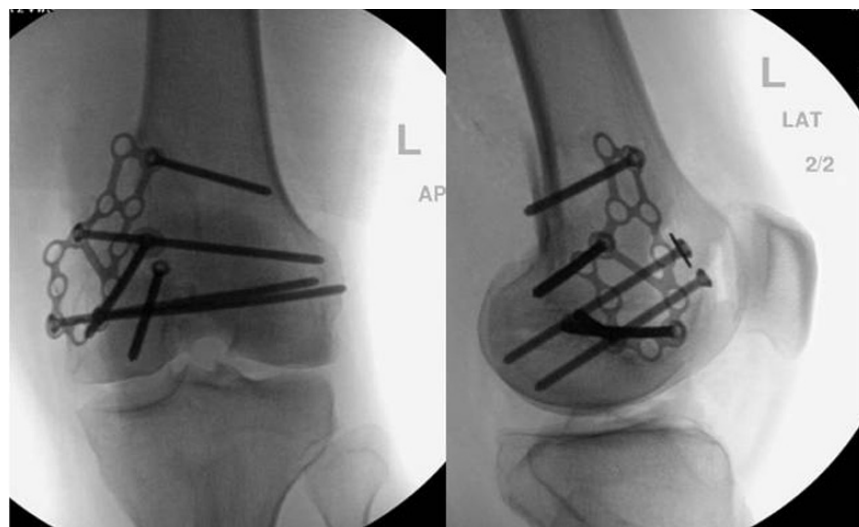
Radiographic evaluation after open reduction and internal fixation.
